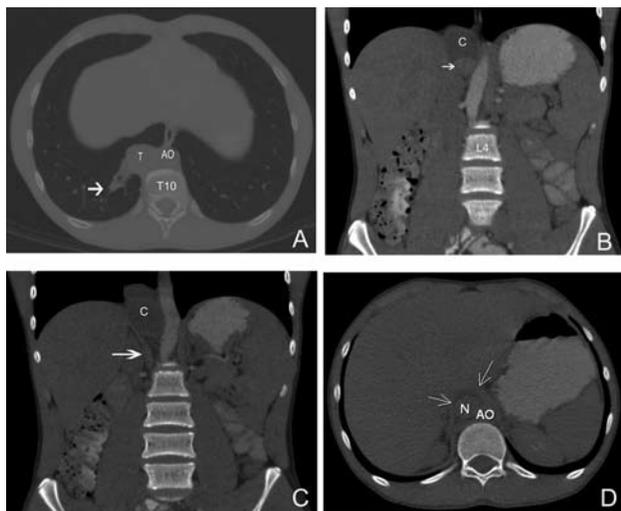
A. CT, axial view, thoracic window at T10 level shows a paraaortic, right anterolateral tumoration (T), with a zone of atelectasis of the posterior pulmonary segment of the right inferior lobe (arrow). B. Coronal view, abdominal window, arterial phase at L4 level confirms the presence of a thin-walled cystic tumoration (C) and a nodular-like lesion in its interior (small arrow). C. Bilobulated shape of the lesion above the diaphragmatic crura (arrow). D. CT, axial view, abdominal window, venous phase at T12 shows the relationship between the intracystic node (N) and the aorta (AO) with the diaphragmatic crura (large arrow). T, tumoration; AO, aorta; C, cystic lesion; N, nodular-like lesion.
